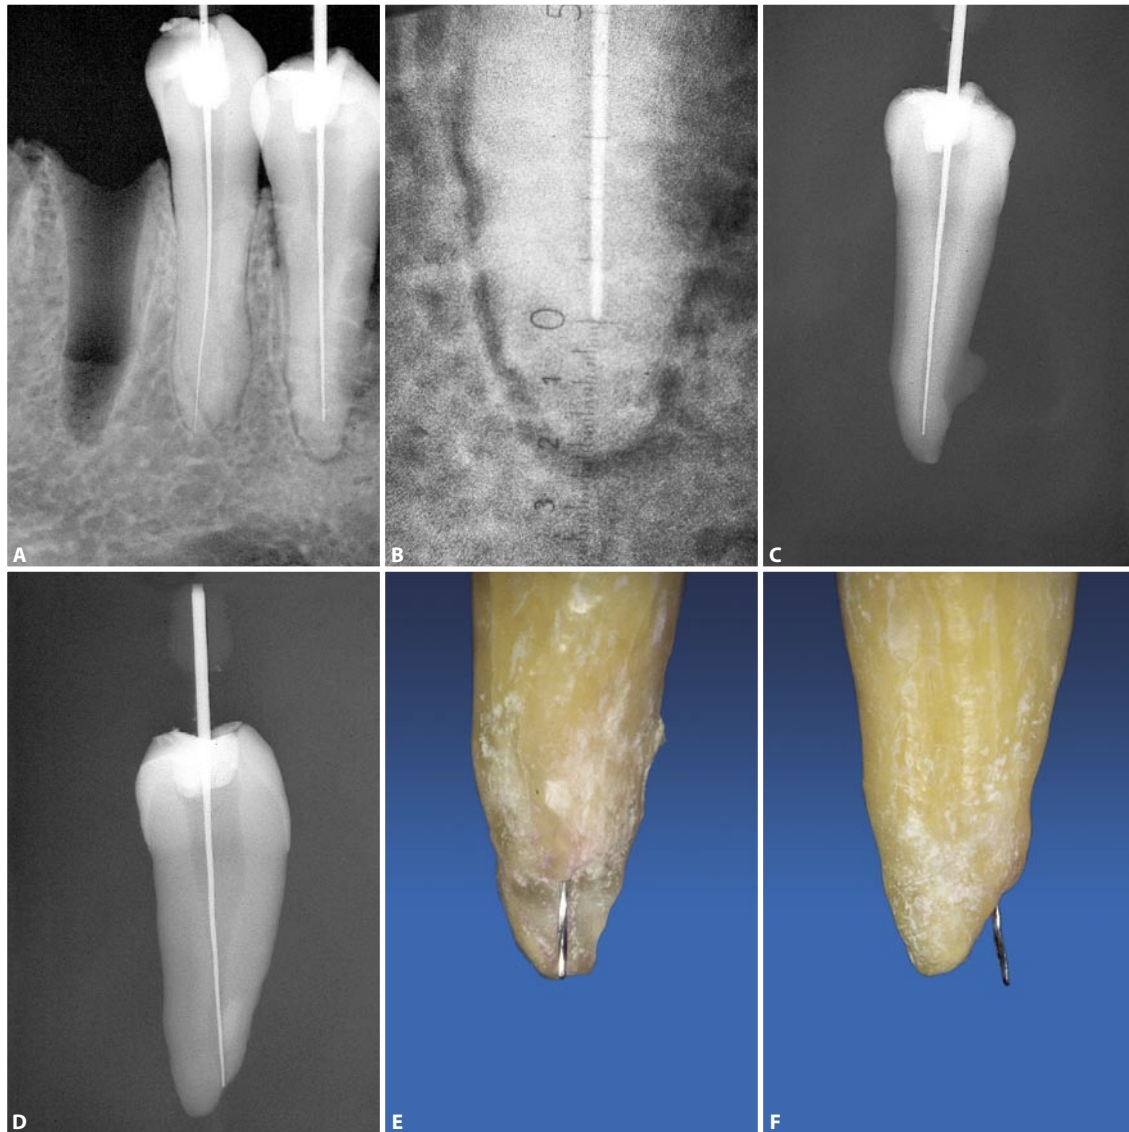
A. One of the research mandibles. In the first lower left premolar the instrument is at the exact radiographic terminus of one of the two canals, while in the second premolar it is visibly short. B. The measurement on the radiograph with a millimeter rule shows it to be 2 mm short of the radiographic apex. C. The extracted tooth radiographed outside of the alveolus. D. The tooth radiographed in a mesio-distal projection. The instrument is at the foramen, but it opens buccally on the root surface and would not be identifiable with a normal radiographic projection. E, F. Note how much the file would need to extrude from the apex to be at the radiographic apex. What would it mean in a case like this to remain 0.5 mm short of the radiographic apex?
